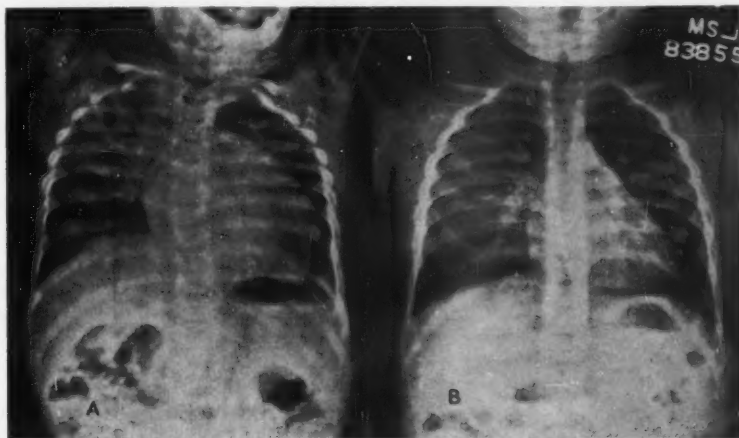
(a) Roentgenogram of the chest of infant one year of age with evidence of ventricular septal defect. Note the globular heart and the increased vascularity of the lungs. (b) Roentgenogram of chest five months following closure of the septal defect. The change in the shape of the heart, and the decreased vascularity of the lungs are striking.
